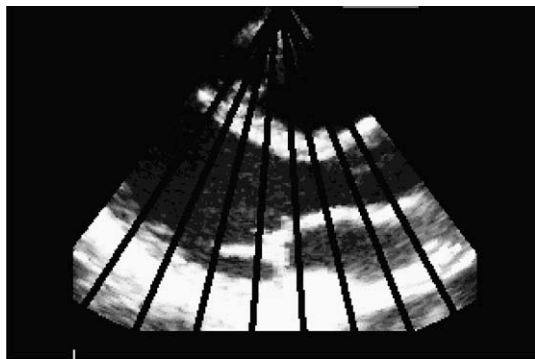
Complete image generation from one ultrasound beam.
